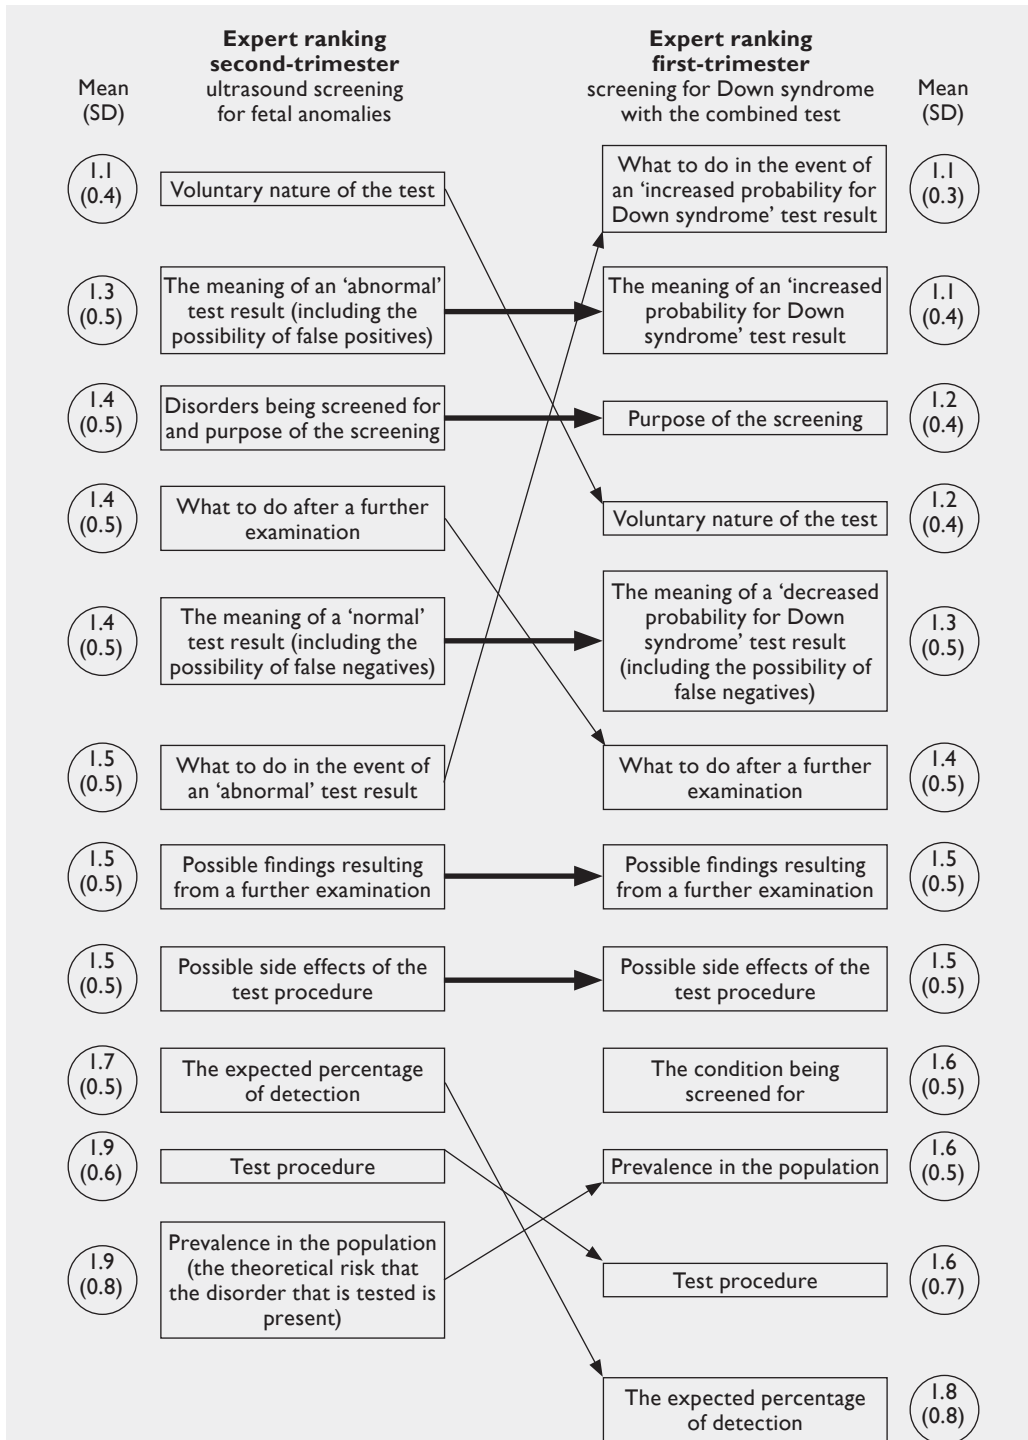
Expert rankings of knowledge domains relevant for informed decision-making on second-trimester ultrasound screening and on first-trimester screening for Down syndrome, showing domains which differed (—) and those which were similar (—) in rank between the two examinations.
